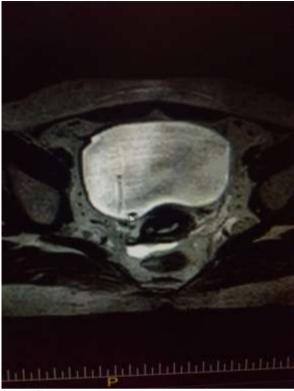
MRI Abdomen showing an intravesical IUCD.
